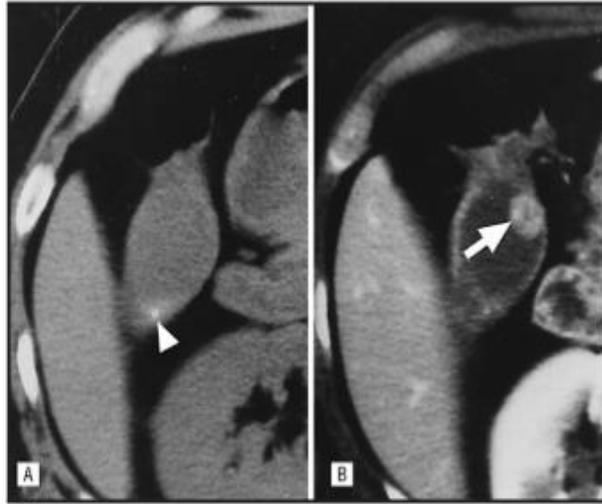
CT Scan showing GB Polyp
